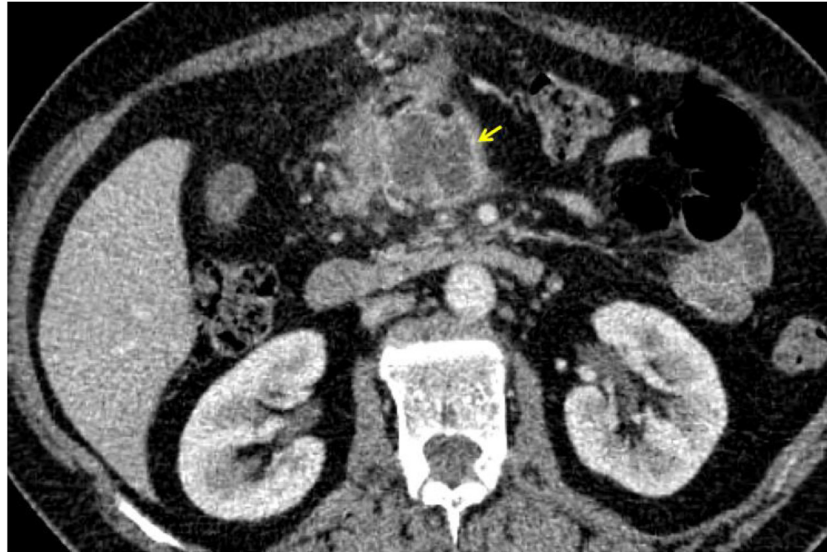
Axial enhanced computed tomography of the abdomen showing a large necrotic peritoneal mass (yellow arrow) with infiltration of surrounding fat.
